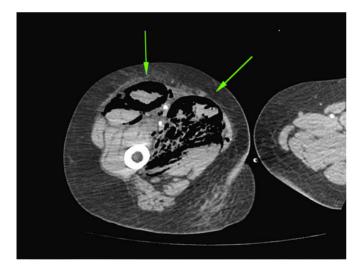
CT scan image showing disruption of right quadriceps muscle due to clostridial myonecrosis.
